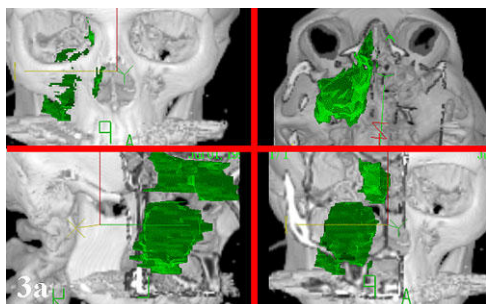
primary maxillary reconstruction after tumor resection. Dimensions of the anaplastic carcinoma only visible in the CT
